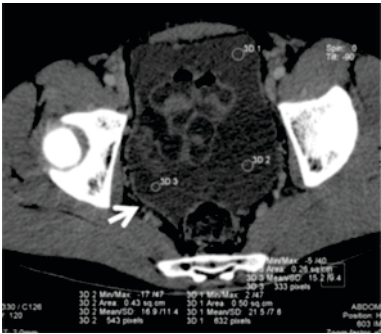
Axial CT image shows high-density ascites with enhancing peritoneum in the pelvis (arrow).
